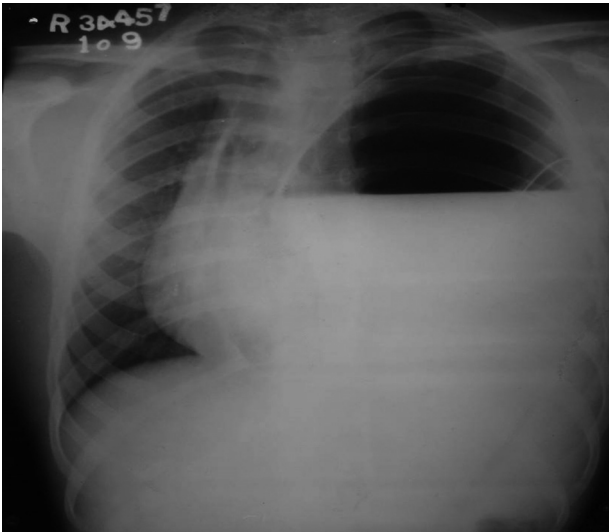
Chest radiograph (postero-anterior view) showing air fluid level on the left side with intercostal drain *in-situ*.
